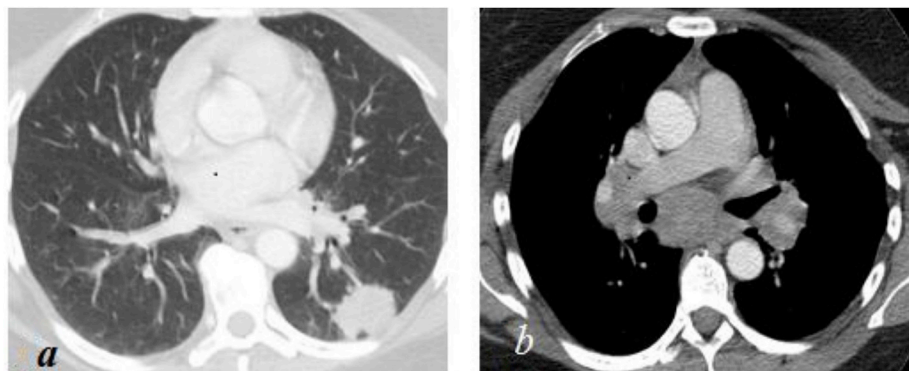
1a, 1b: Chest CT showing a left lower-lobe mass and enlarged mediastinal lymph nodes.
